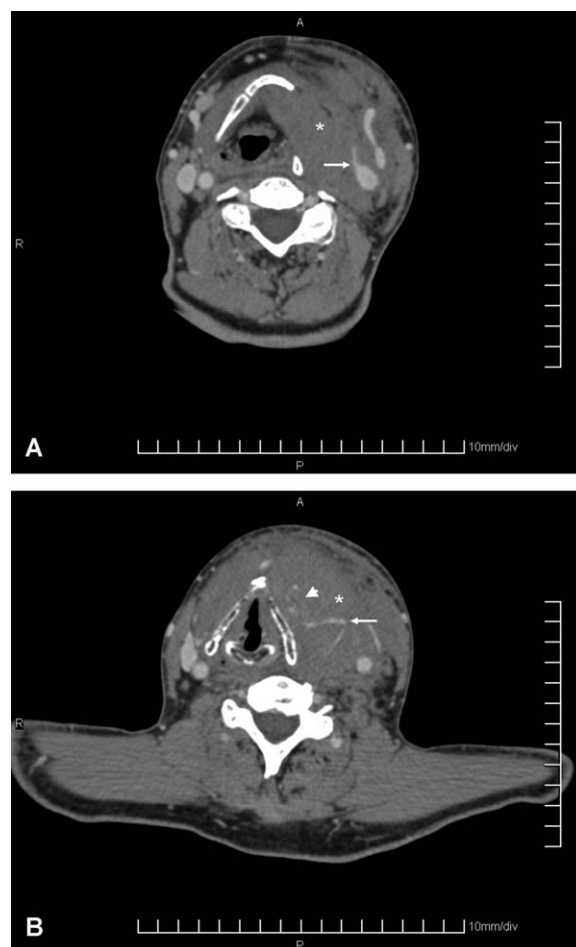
Contrast-enhanced angiographic CT scans shows the dimensions of the cervical hematoma (*) with lateralization of the trachea. Departure of the left superior thyroid artery from the external carotid artery in height of the bifurcation (A, arrow) and branching of the superior thyroid artery (B, arrow) with extravasation of contrast media within the hematoma (arrowhead).
